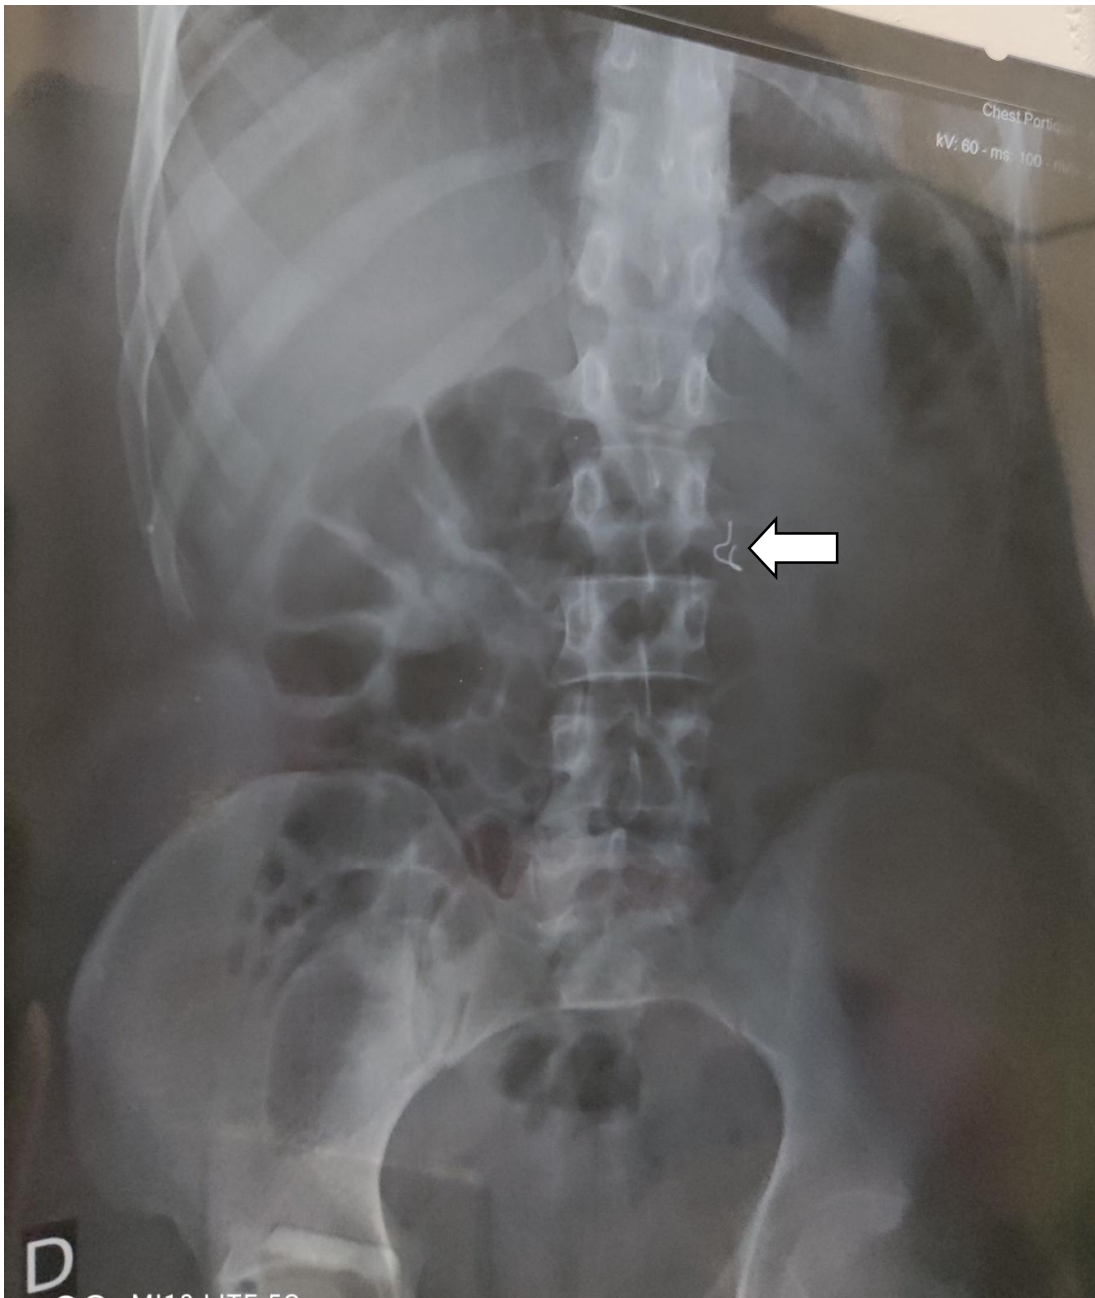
Plain abdominal radiography: foreign body.
